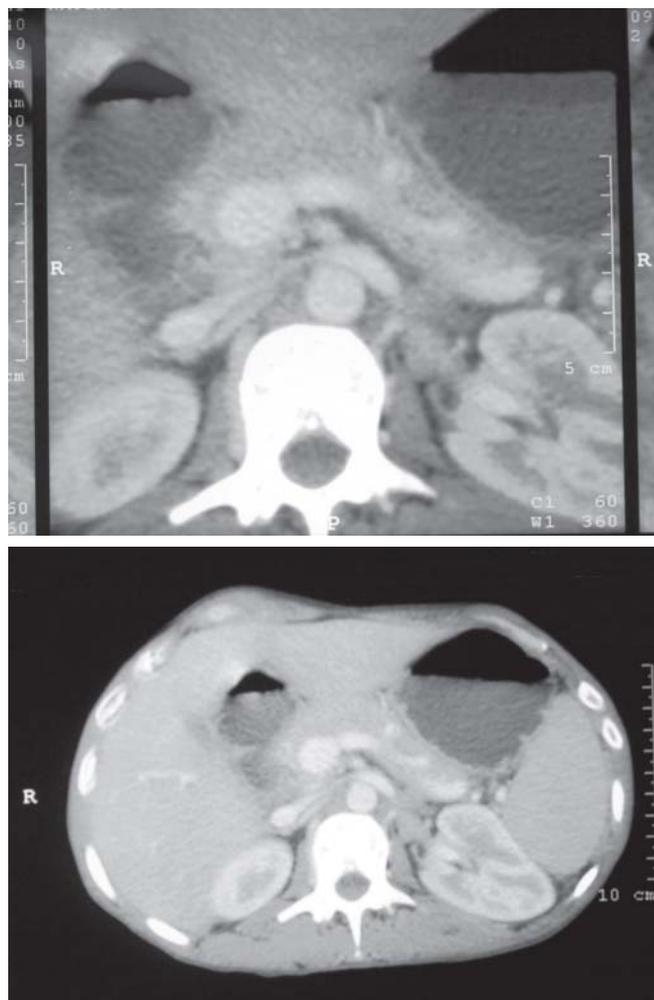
CT scan of abdomen showing two well-defined lesions in the body and tail of pancreas with surrounding lymphadenopathy
